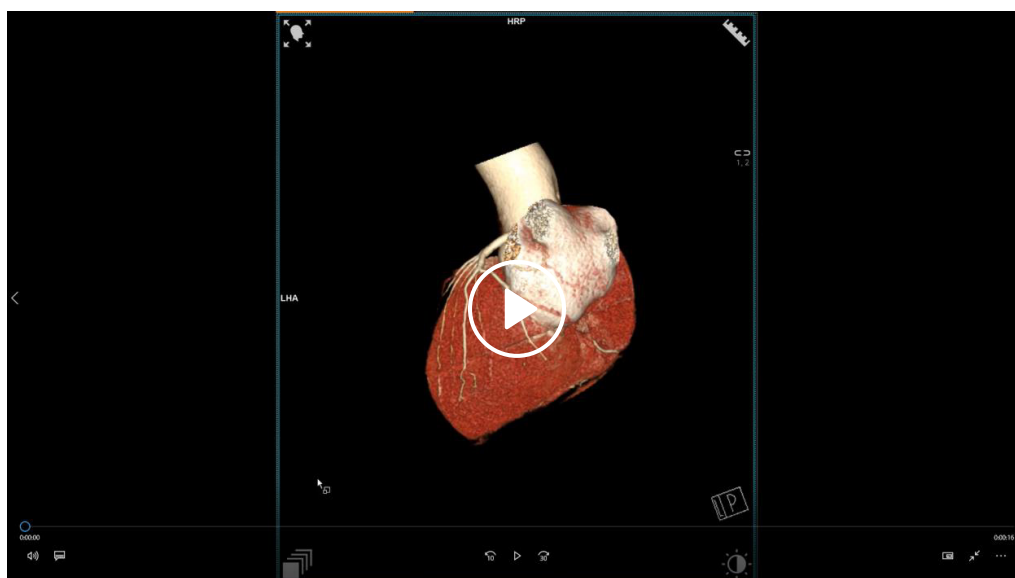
(A, B) Volume-rendered images, (C) axial image, and (D) curved multiplanar reconstruction of computed tomography angiography show the RCA splitting into two trunks. The anterior good-sized trunk (white thick arrow) is seen coursing along the acute margin of the right heart and is seen reaching the distal aspect of the posterior interventricular groove and continuing as the distal posterior descending artery (white arrowhead). The posterior trunk (yellow thick arrow) is seen coursing along the right atrioventricular groove, subsequently entering the RA and having an intra-atrial course (dotted circle) for a length of 3 cm. The posterior trunk is then seen emerging out of the right atrium near the crux of the heart and gives rise to a proximal posterior descending artery along the proximal posterior interventricular groove. RCA: right coronary artery; RA: right atrium
